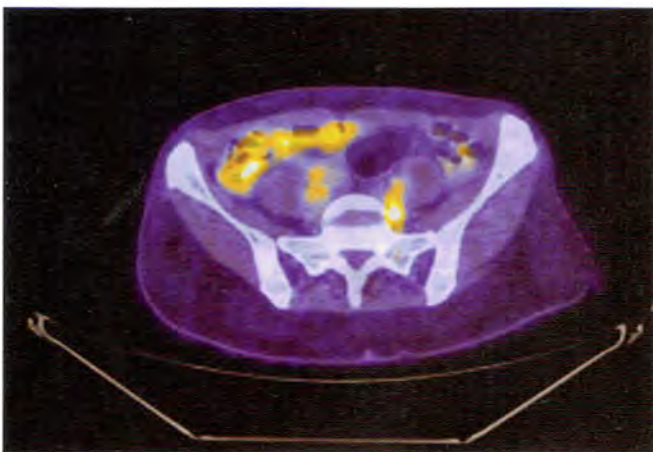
There is a left iliac lymph node that measures 1.0 × 0.8 cm with a SUVmax of 6.7.
